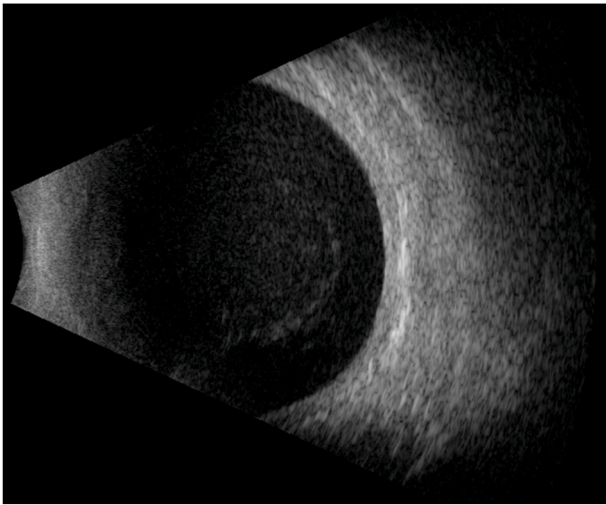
Patient 2: B scan ultrasound scan showing moderate - dense vitreous opacities.
